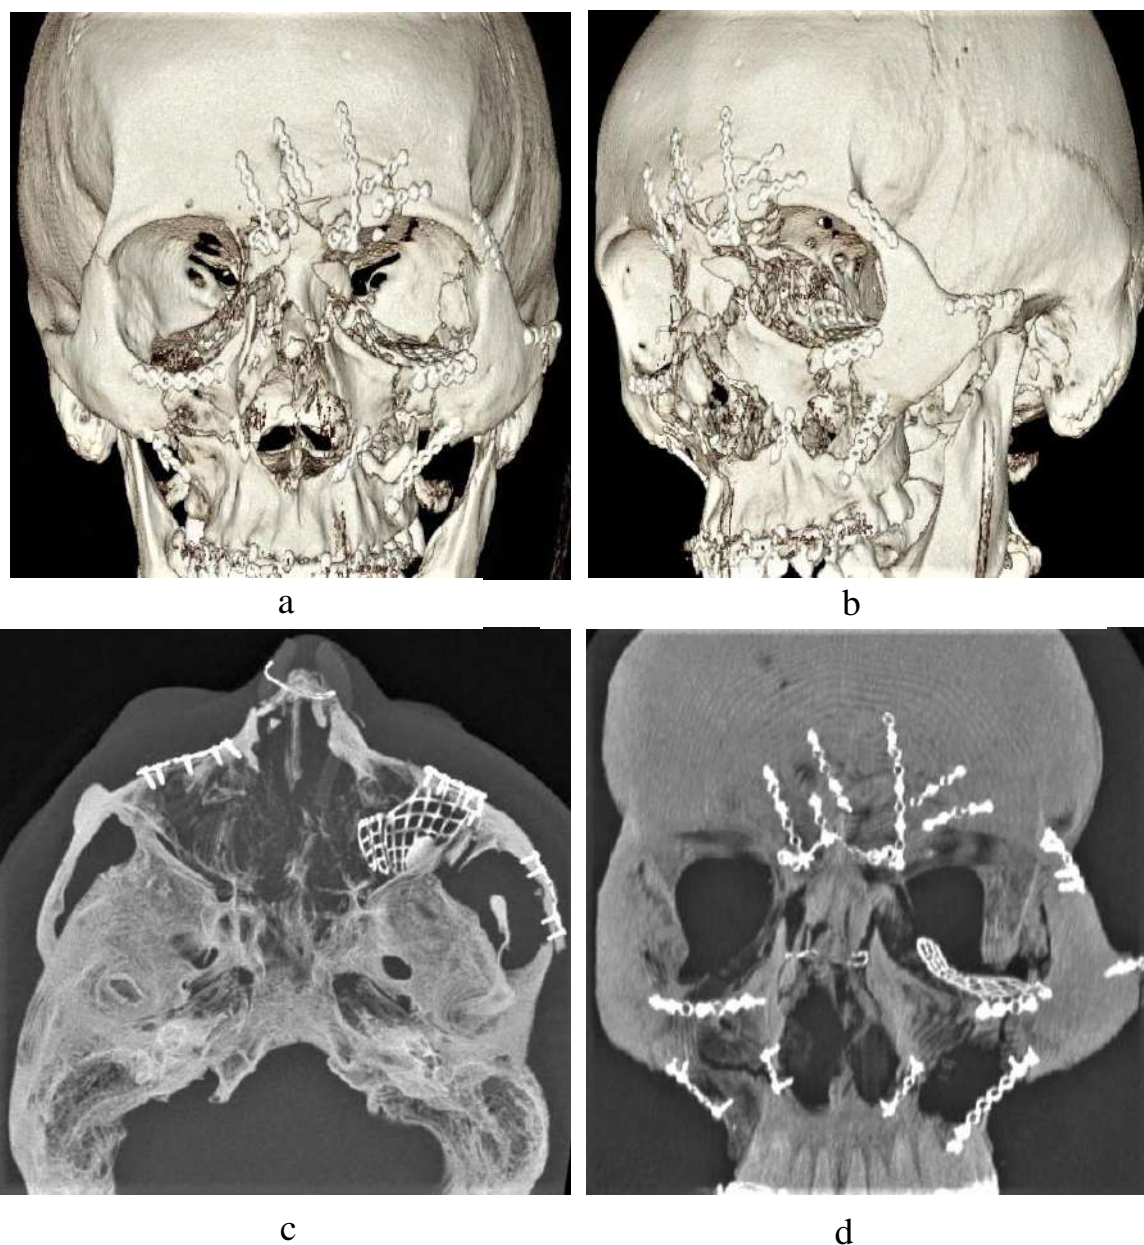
CT scan of the skull of the injured patient B., 26 years old, after the reconstructive-restorative surgeries: a) anterior view; b) left lateral view; c) coronal projection; d) axial projection.
